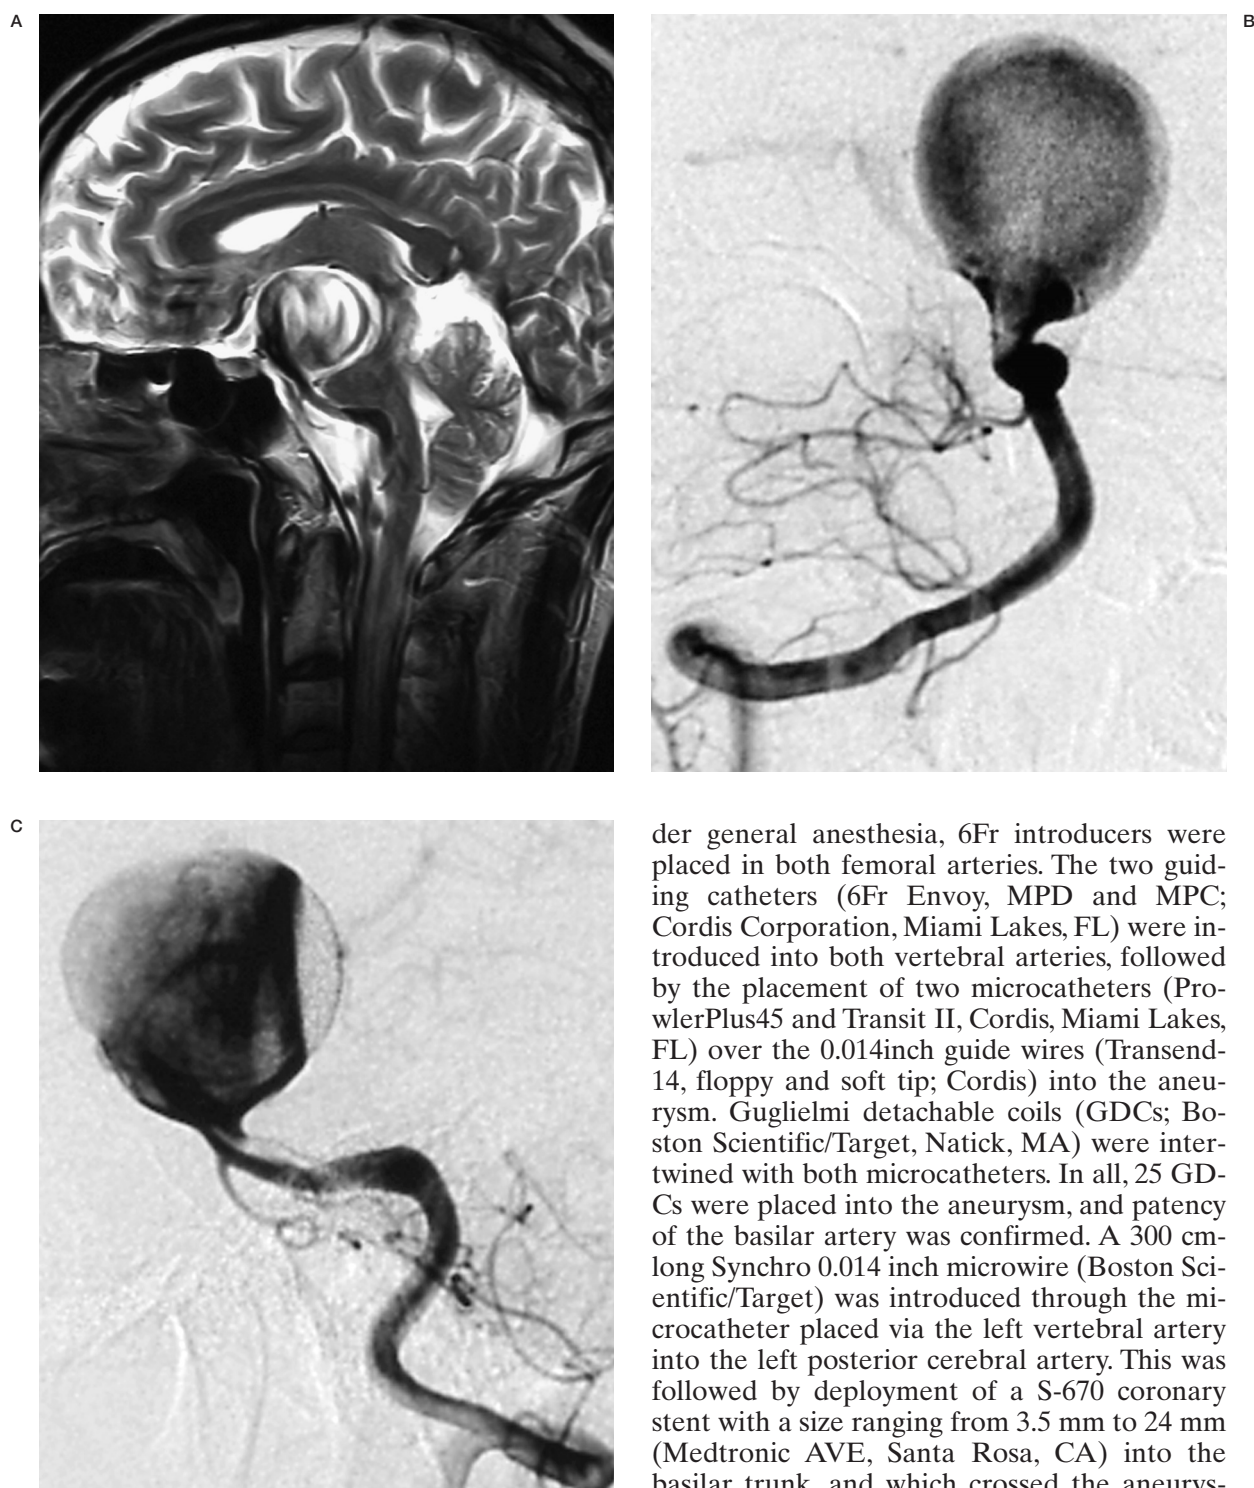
MRI (T2WI) demonstrates a giant aneurysm compressing the midbrain and the upper pons (A). Right vertebral angiograms, antero-posterior projection (B) and lateral projection (C) demonstrate a giant aneurysm located in the basilar trunk distal to the anterior inferior cerebellar artery. The maximum diameter of the aneurysm is 32 mm and the size of the neck 18 mm.
